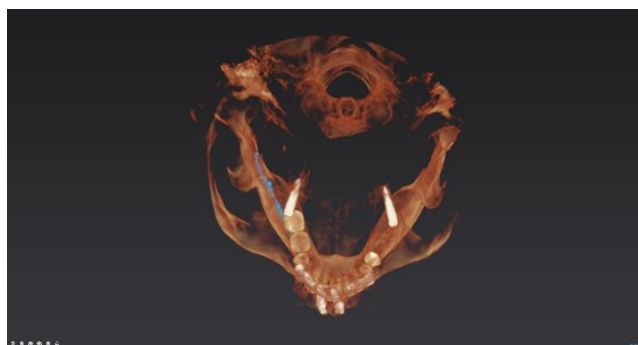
The 3D Cbct scan confirmed the right apex engagement of the pterygoid implants in the pterygoid region.*
